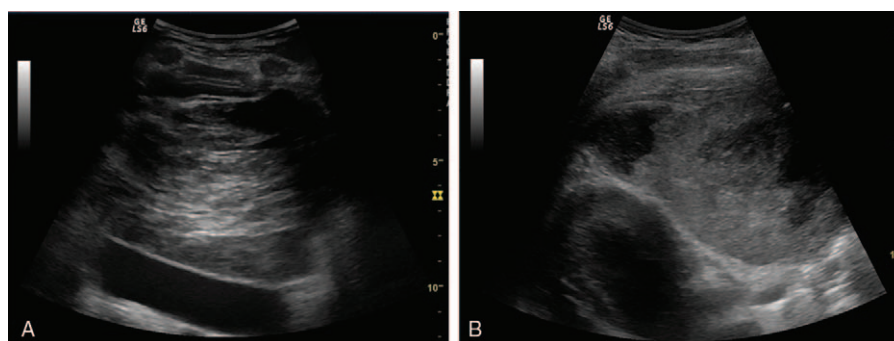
A, Parasternal sagittal approach of an inhomogeneous tumor (hypoechoic peripherally and hyperechoic centrally) adjacent to descending thoracic aorta—SGCT. B, Large left prevascular mediastinal tumor with mixed structure—multiple hypoechoic necrotic intratumoral areas—Yolk sac tumor (NGCST).
